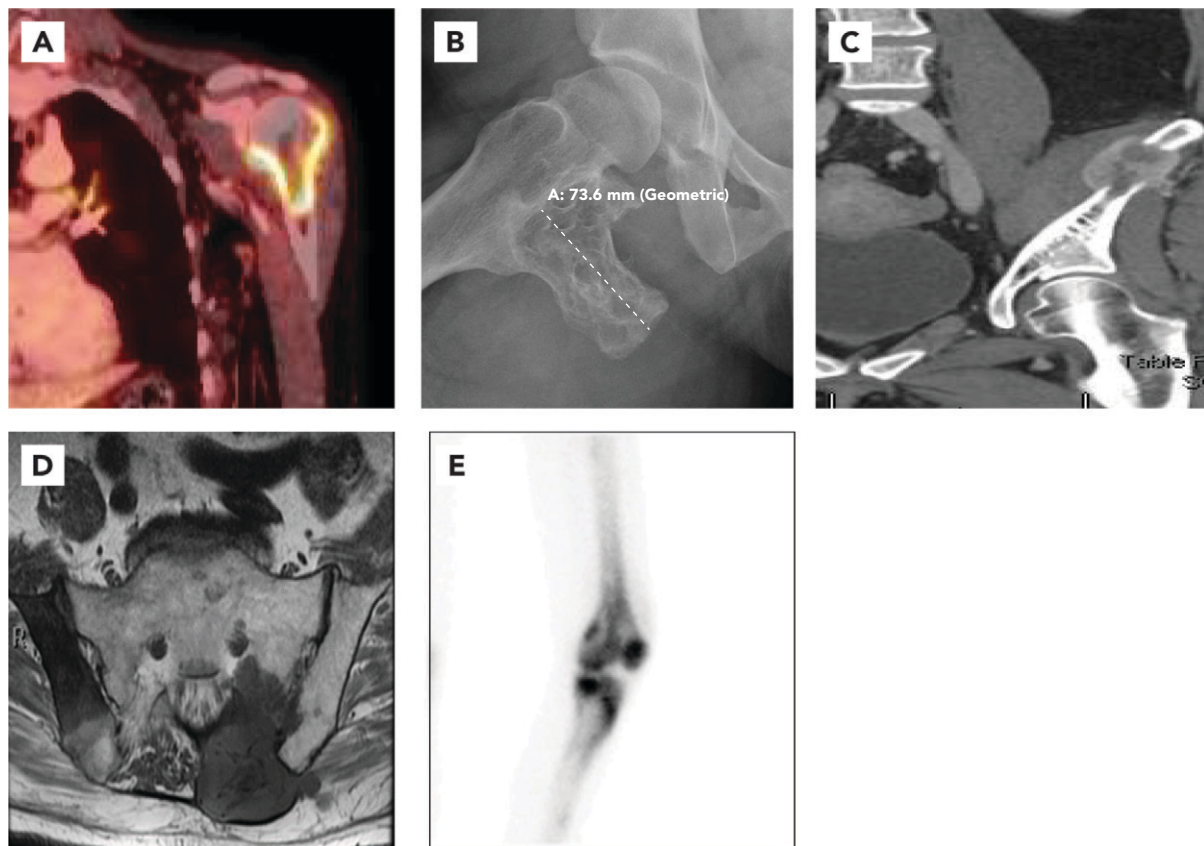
Typical diagnostic images of bone lesions with radiographic reports. (A) PET/CT scan of a metabolically active metastatic bone lesion involving the left humeral head-neck demonstrating cortical disruption. (B) Plain radiographs of the hip showing large exostosis of the proximal right femur and a cartilaginous lesion of the right ilium. (C) CT scan of a metastatic lesion arising from the left iliac bone infiltrating the iliacus muscle. (D) MRI of the large left sacral ala mass invading the left S1-S3 foramen with effacement of the fat surrounding the S2 and S3 nerves. (E) Nuclear medicine bone scan showing focal tracer uptake worrisome for metastatic disease in left distal femur and left proximal tibia.
